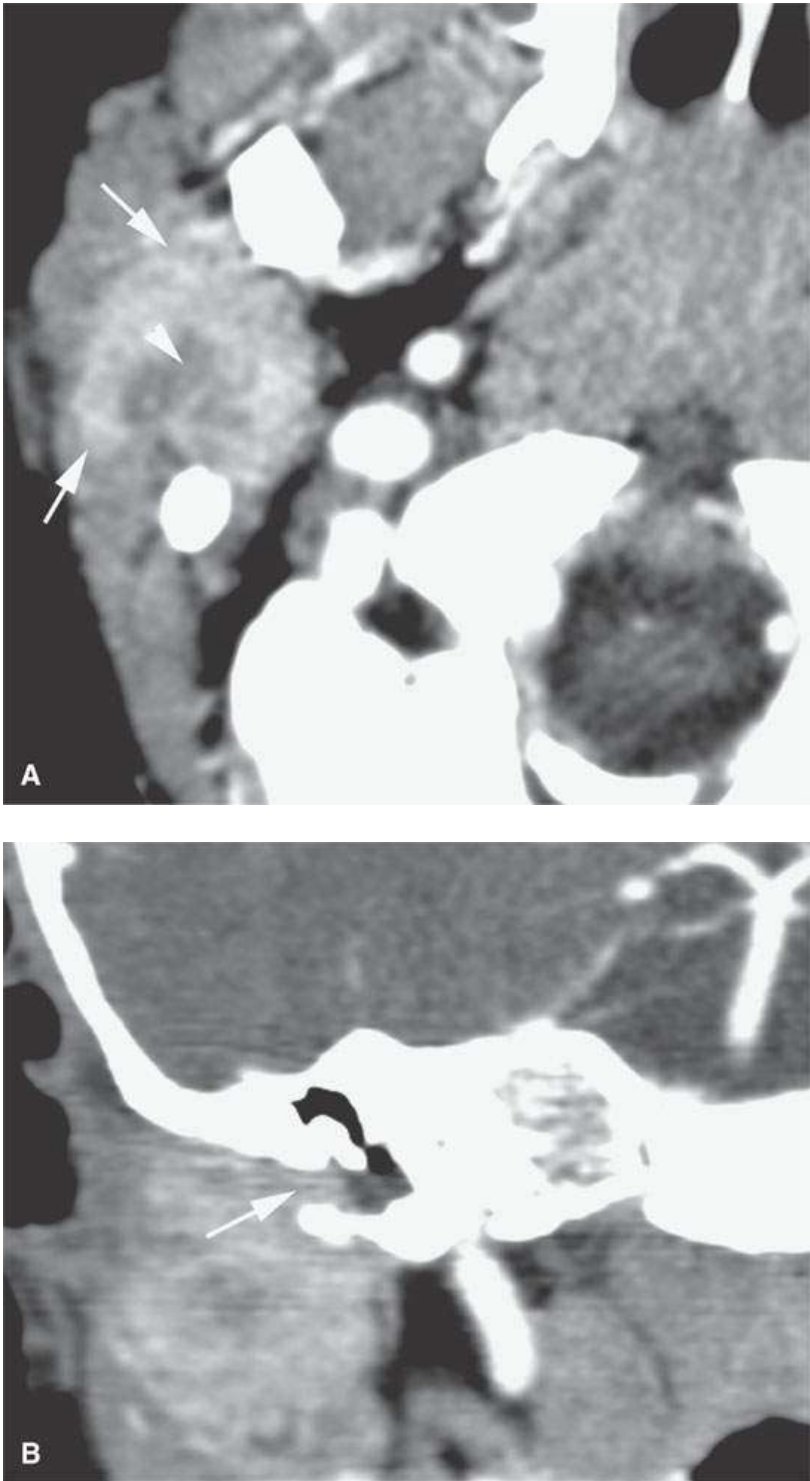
Contrast-enhanced computed tomography of a 4 year old with mucoepidermoid carcinoma of the parotid gland. A: The mass is well circumscribed, but its margins (arrows) suggest an invasive nature; the low-density center (arrowhead) is nonspecific. B: The aggressive nature of the mass is clear from its invasion of the external auditory canal (arrow).
